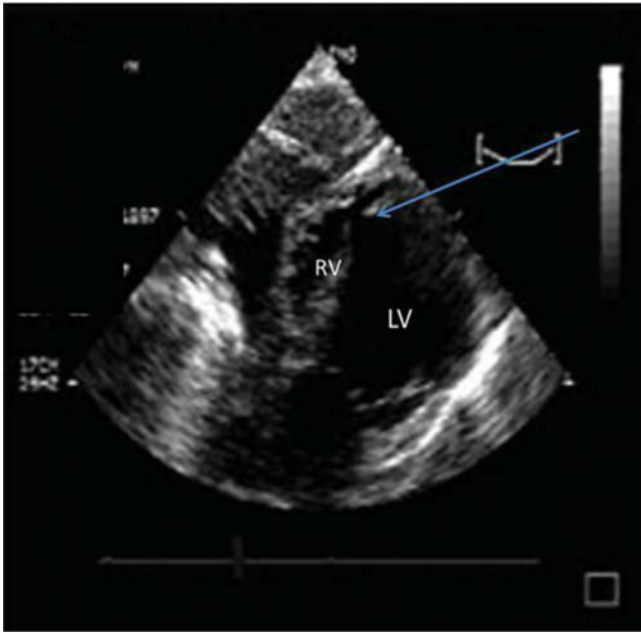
Subcostal four-chamber view of transthoracic two-dimensional echocardiogram in a 68-year-old woman who developed shock 2 weeks after extensive MI. A rupture of the ventricular septum is noted (*arrow*). LV, left ventricle; RV, right ventricle.
